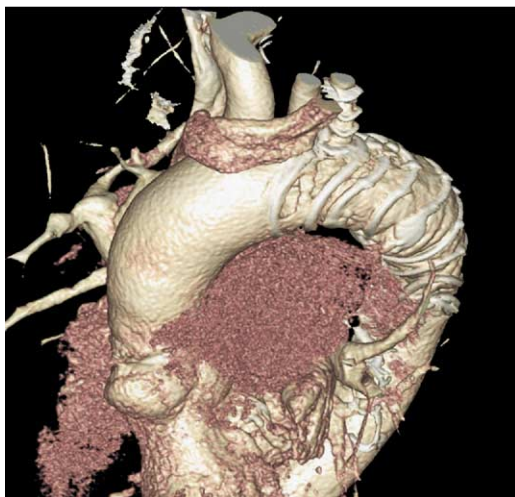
Three-dimensional reconstruction of the computed tomographic scan demonstrating satisfactory stent-graft position and a patent left subclavian artery.
